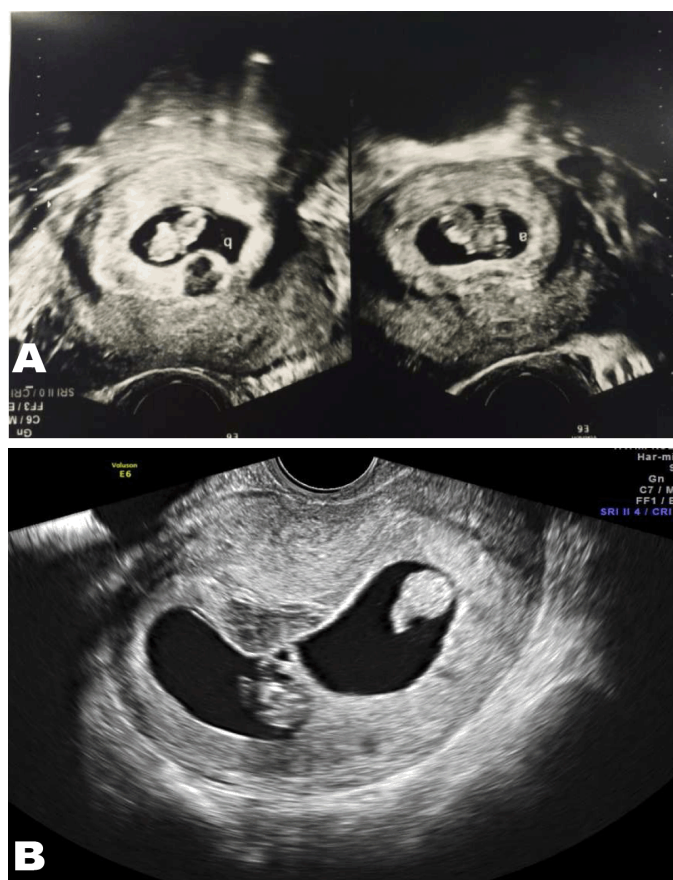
(A, B): Ultrasound images showing both twins. Twin B is close to the ectopic pregnancy.
